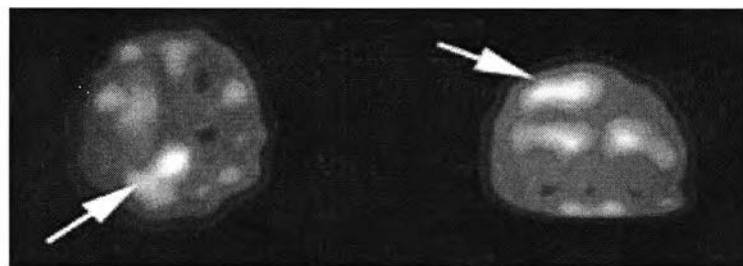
Ictal SPECT in frontal lobe epilepsy
